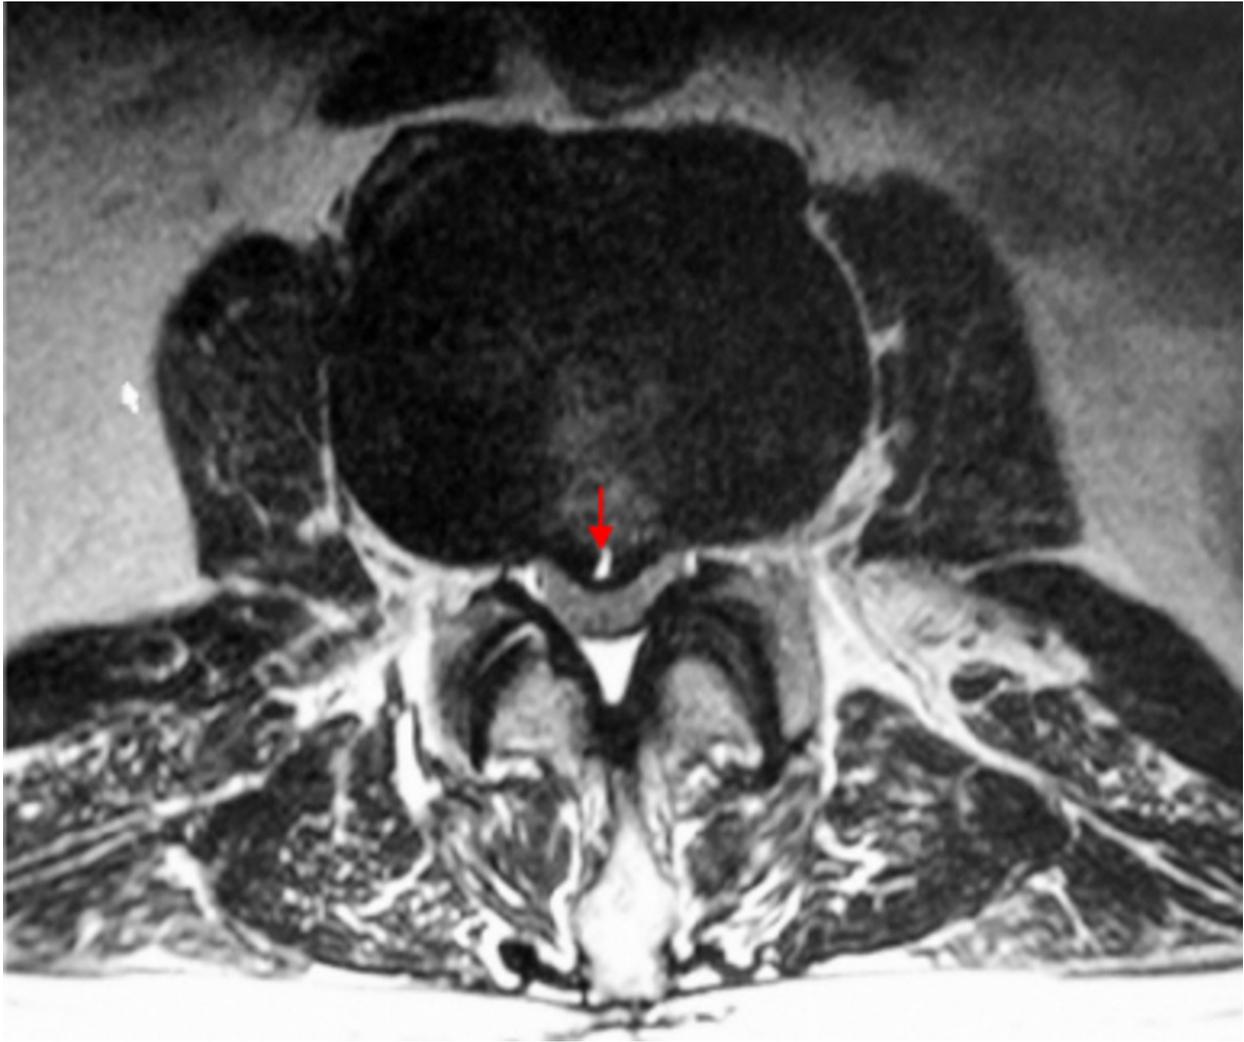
Axial T2 Weighted Lumbar Spine MRI image showing L2/L3 Central Focal Disc Protrusion With Central Annular Disc Tear Distorting The Thecal Sac At This Level
